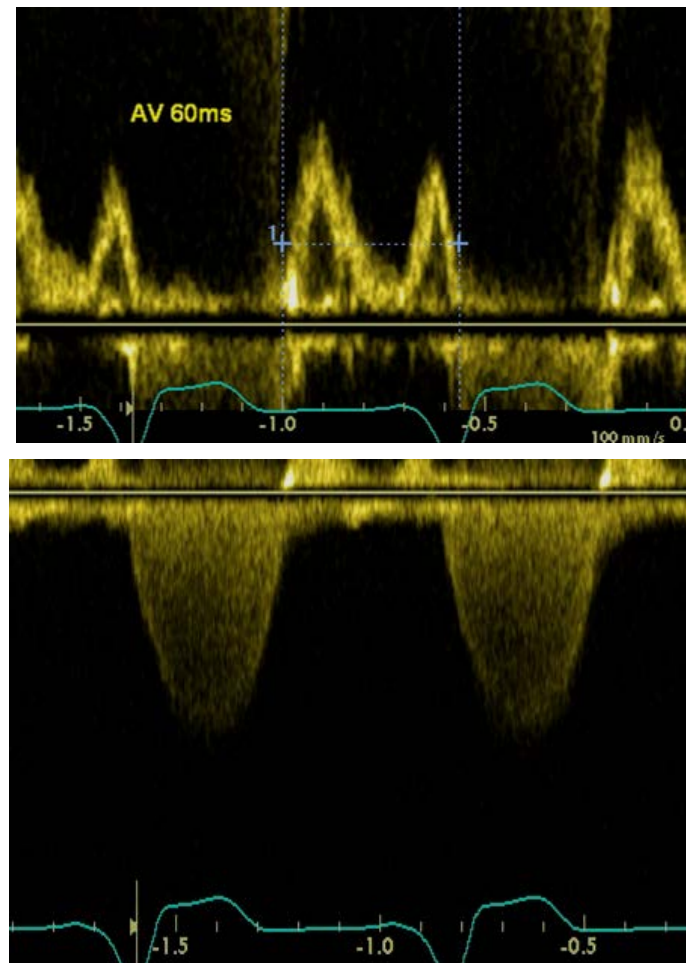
(A) Continuous-wave Doppler recording of severe mitral regurgitation and (B) left ventricular filling. Note the equalization of left atrial and left ventricular pressures in early diastole, ending retrograde flow at A2, short isovolumic relaxation time, high left ventricular filling velocities in early diastole, and third heart sound. (C) Continuous-wave Doppler from a patient with moderate MR, ending shortly beyond A2.
